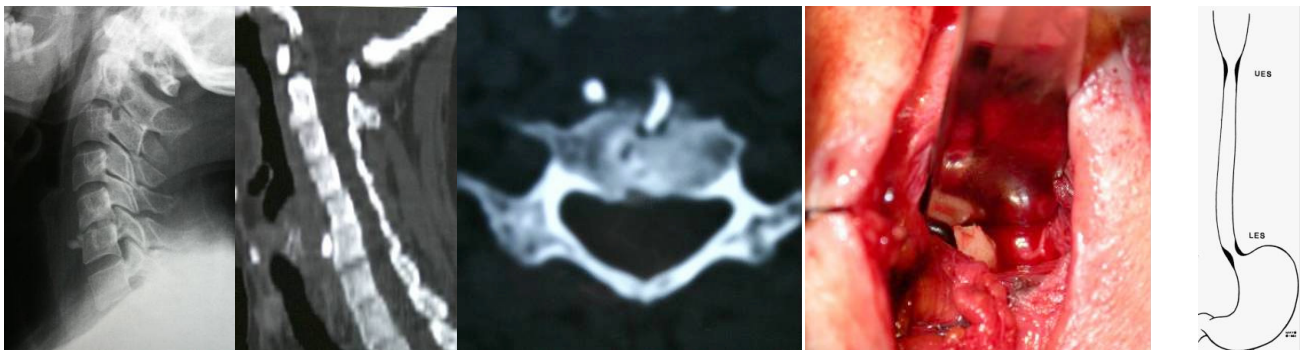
Lateral cervical spine radiograph showed fracture of the fibular allograft at C5 – 6. A portion of fractured graft was extruded toward the esophagus.
